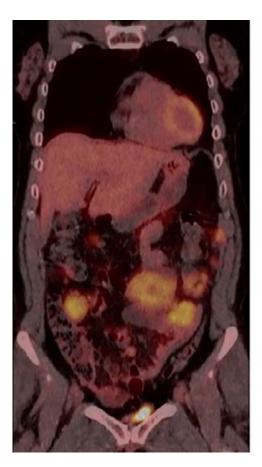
PET-CT revealed extensive progressive malignant disease one year after initial surgery
